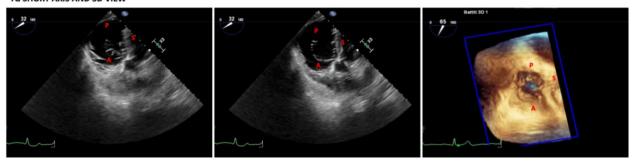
Echocardiographic assessment of the tricuspid valve. Main TOE views for tricuspid valve assessment. A, anterior leaflet; P, posterior leaflet; S, septal leaflet; CS, coronary sinus. DE, deep-oesophageal; ME, mid-oesophageal; RV, right ventricle; TG, transgastric; 3D, tridimensional.
